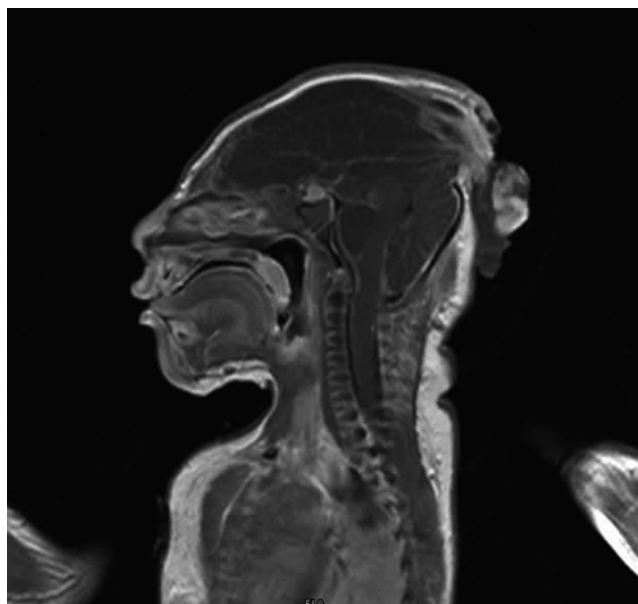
Sagittal T1 MRI scan of a child with severe cranial dysraphism, with a pronounced brain malformation and encephalocele
